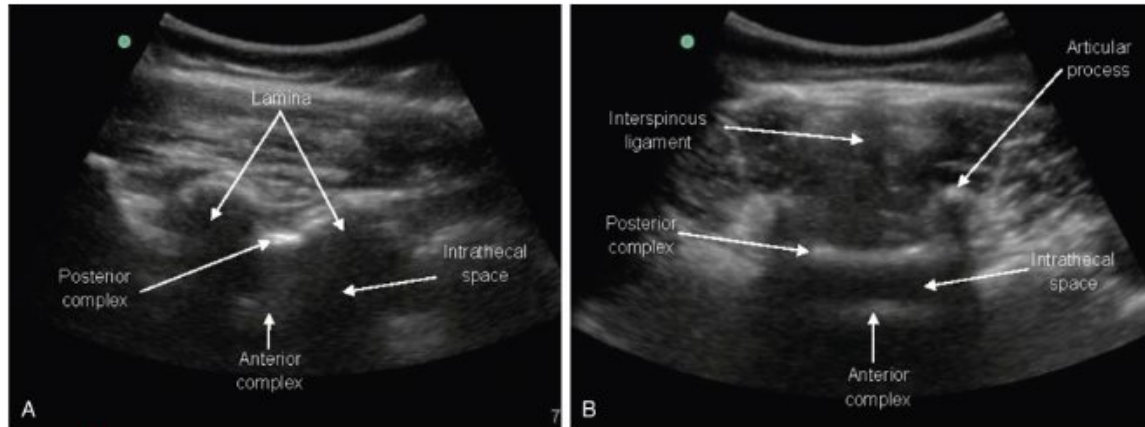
Ultrasound paramedian sagittal oblique (A) and midline (B) views of the lumbar spine. In the paramedian sagittal oblique view, the ultrasound probe is placed parallel and slightly lateral to the midline of the spine. In this view, the lumbar laminae appear as hyperechoic structures in a classic “sawtooth” pattern. The ligamentum flavum, posterior epidural space, and dura are often not individually distinguishable, appearing as a single hyperechoic structure, referred to as the posterior complex. Similarly, the anterior complex also appears as a single hyperechoic structure and is composed of the anterior epidural space, anterior dura, posterior longitudinal ligament, and posterior aspect of the vertebral body.
